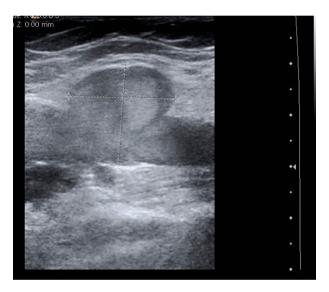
Ultrasound image — brachial vein venous aneurysm in the right upper limb
